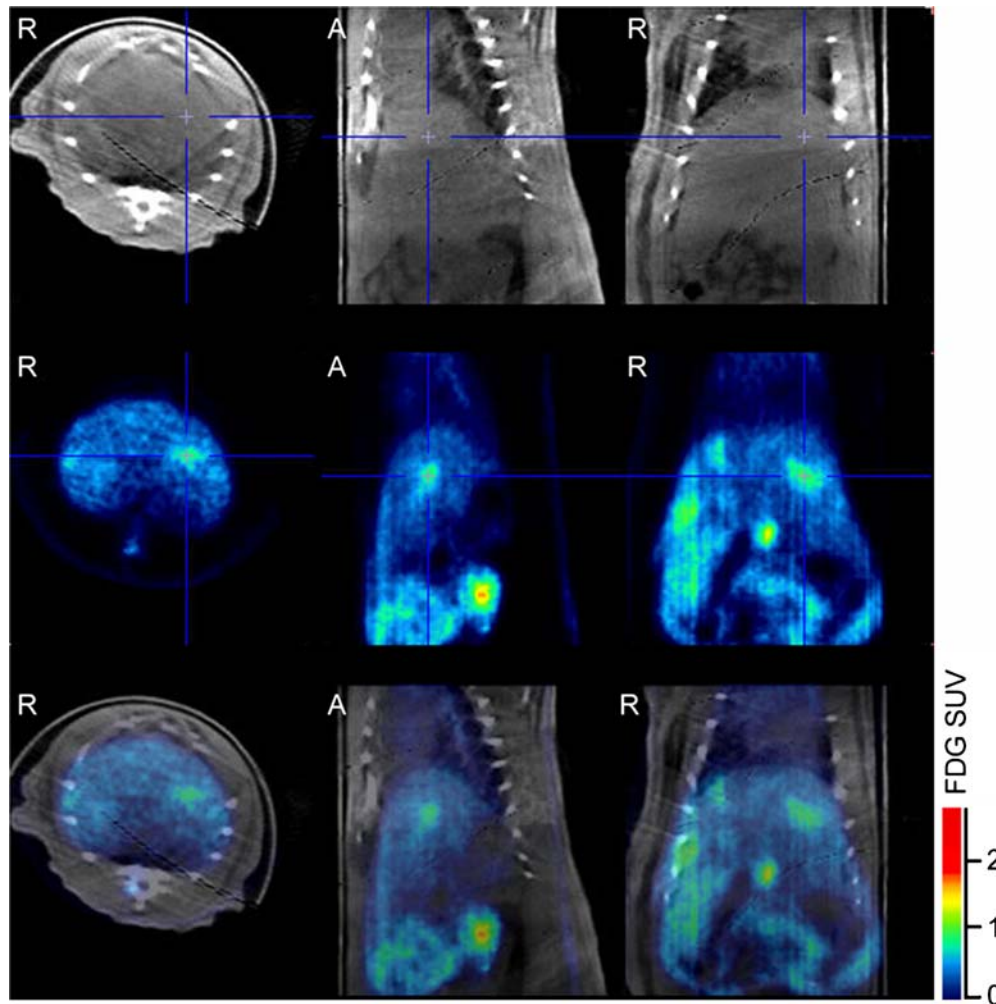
Transverse, sagittal, and coronal views of CT and PET studies. CT and PET images were fused to improve interpretation accuracy (*third column*).
